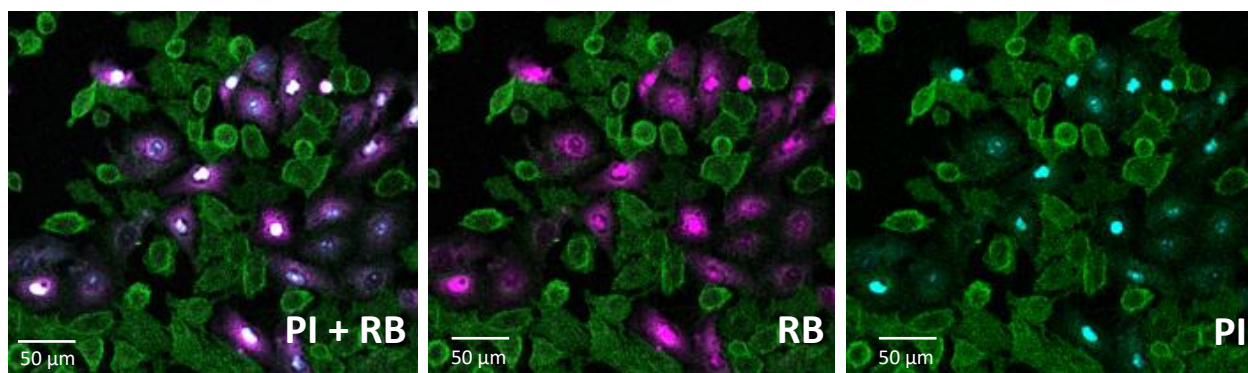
Representative image of Rose Bengal and PI distribution in A549 cells after the cells were exposed to ultrasound in the presence of RB, with PI added 30 mins after ultrasound exposure (green colour represents Cell Mask Green, purple – Rose Bengal, cyan – PI). Images show optical channels for RB and PI merged, as well as separately RB and PI channels. Images courtesy of Veerle Brans.
